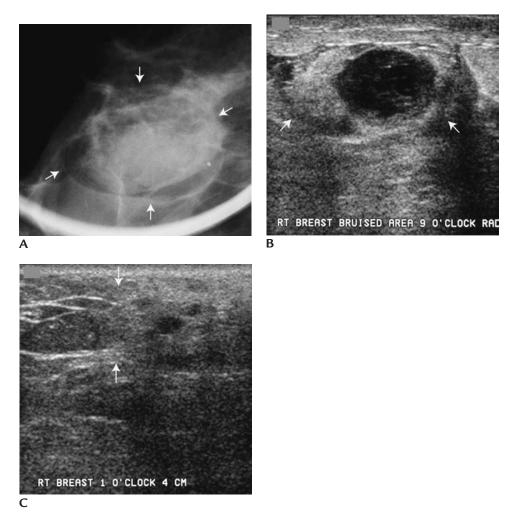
Hematoma. (A) Spot compression view of "bruised" site, right breast. Fat containing mass (*arrows*) with partially indistinct and circumscribed margins. (B) Oval mass (*arrows*) with areas of hyperechogenicity and a cystic space. Posterior acoustic enhancement is seen associated with the cystic component. Normal tissue planes are disrupted. (C) Different patient. Ultrasound demonstrating transition point (*arrows*) between normal tissue planes and hematoma. Increased echogenicity associated with small anechoic areas is seen corresponding to trauma site. Normal Cooper's ligaments with subcutaneous fat seen to the left of the arrows.
